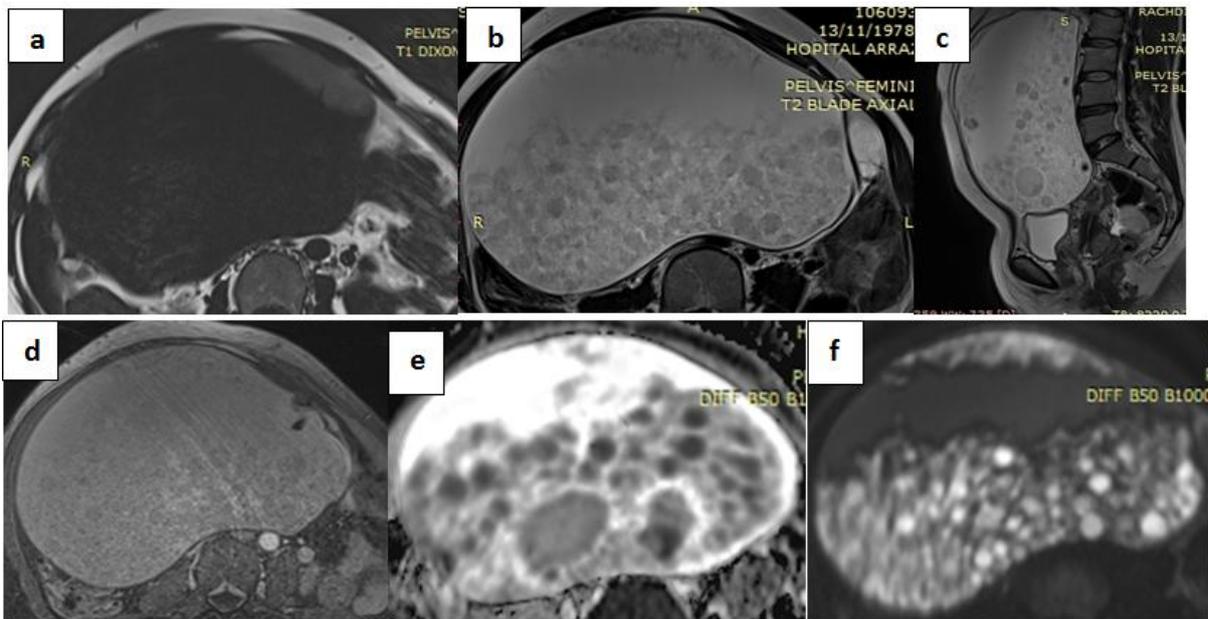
Axial T1 (a) T2 (b) sag T2 (c) axial T1 postcontrast(d) and axial diffusion(e) and ADC map (f) weighted magnetic resonance imaging. Reveals the heterogenous cystic mass containing the floating balls wich chows an intermediate signal intensity in the T1- and T2-weighted séquences and diffusion restriction regarding the k eratin content
